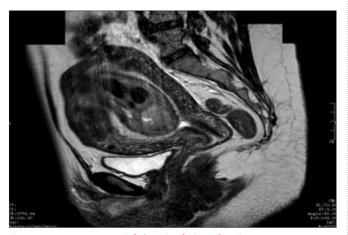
MRI Uterus - Axial / Sagittal view showing cystic spaces within a large intra-cavitary fibroid.
